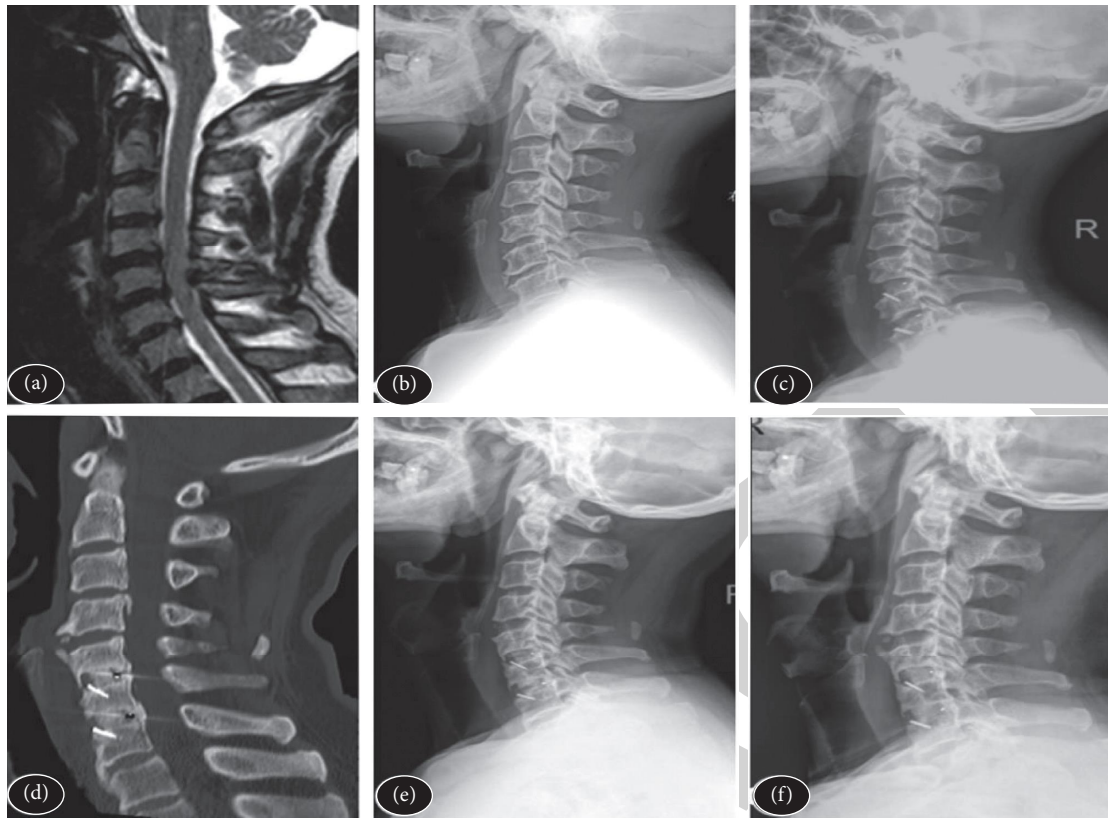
Sagittal MRI(T2) was performed before posterior cervical expansive canal plasty.
